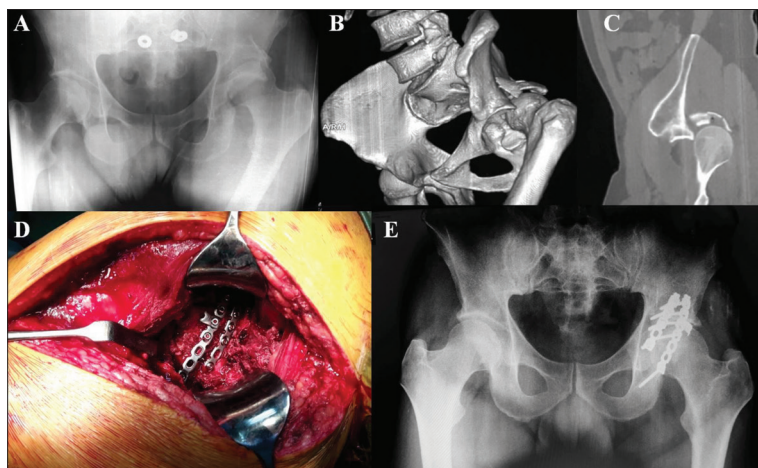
Open reduction and stable internal fixation of acetabular fracture-dislocation; A: X-ray after the injury; B, C: 3D computed tomography (CT) view shows fracture of the posterior wall of the acetabulum and posterior hip dislocation; D: intraoperative view after fracture fixation; E: postoperative X-ray
